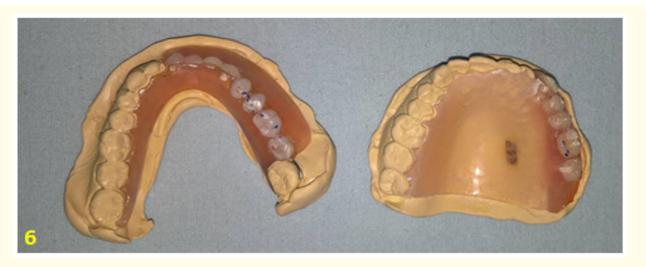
a- Interim Removable Partial Denture, b- Radiographic presentation (OPG).
